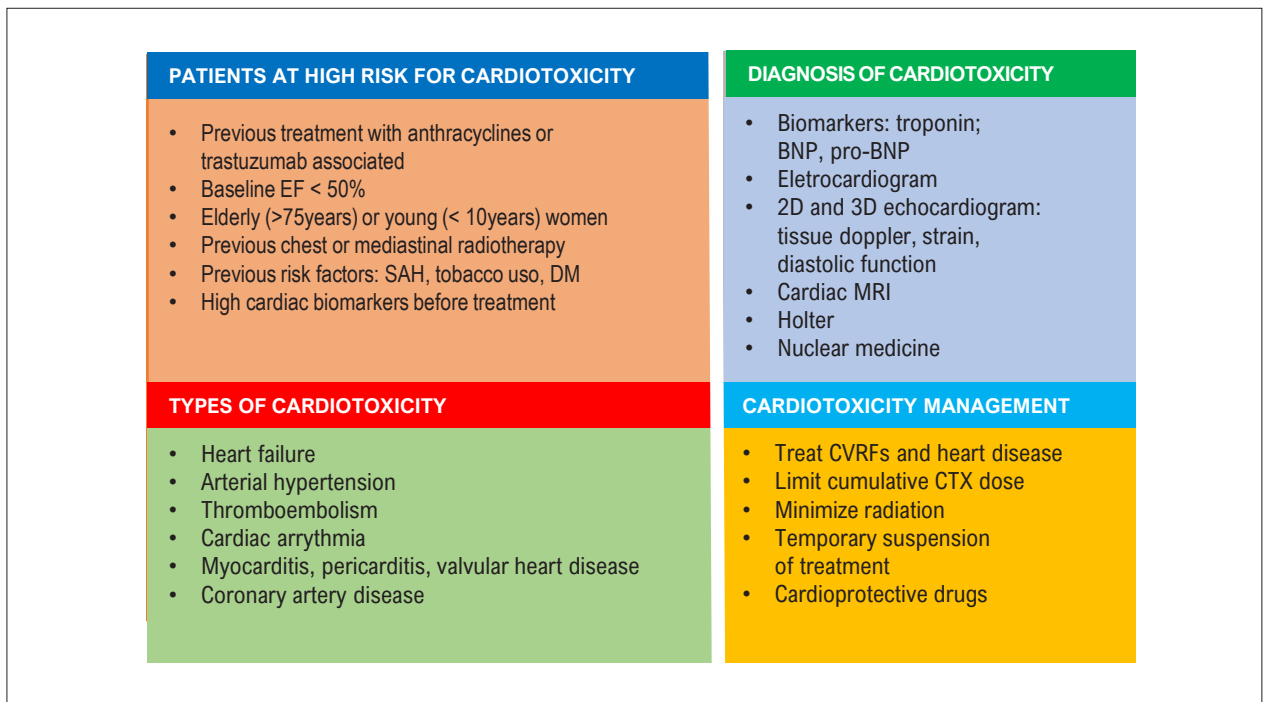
Summary of the major aspects related to cardiotoxicity. 2D: two-dimensional; 3D: three-dimensional; CVRF: cardiovascular risk factor; CTX: chemotherapy; DM: diabetes mellitus; EF: ejection fraction; MRI: magnetic resonance imaging; SAH: systemic arterial hypertension.
